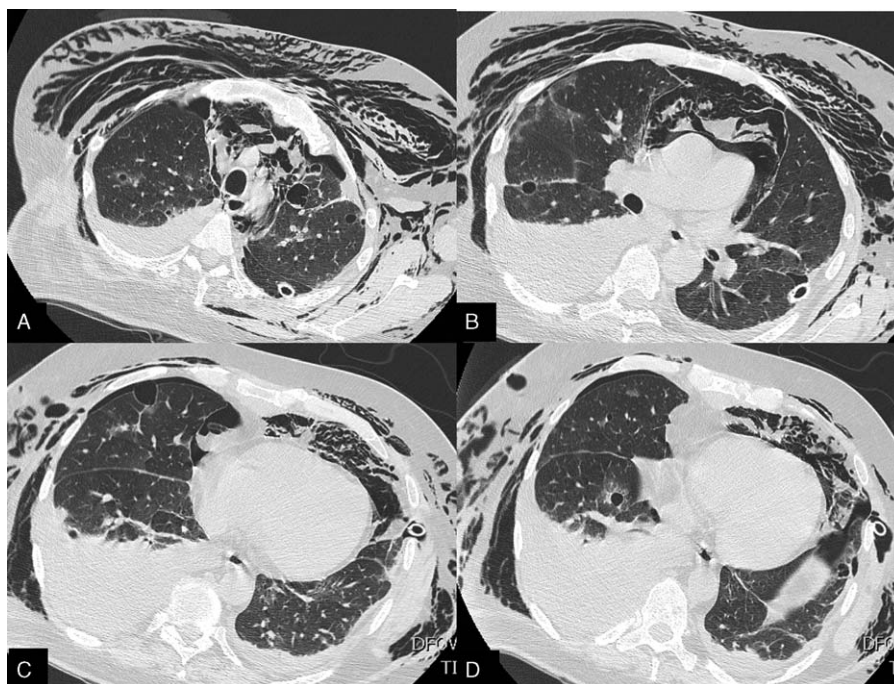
Patient 4. CT scan shows left plural drainage and the onset of bilateral severe subcutaneous emphysema. Pneumothorax is significantly reduced, remaining bilaterally in a small size. A small bilateral pneumothorax and pneumomediastinum are also present.
